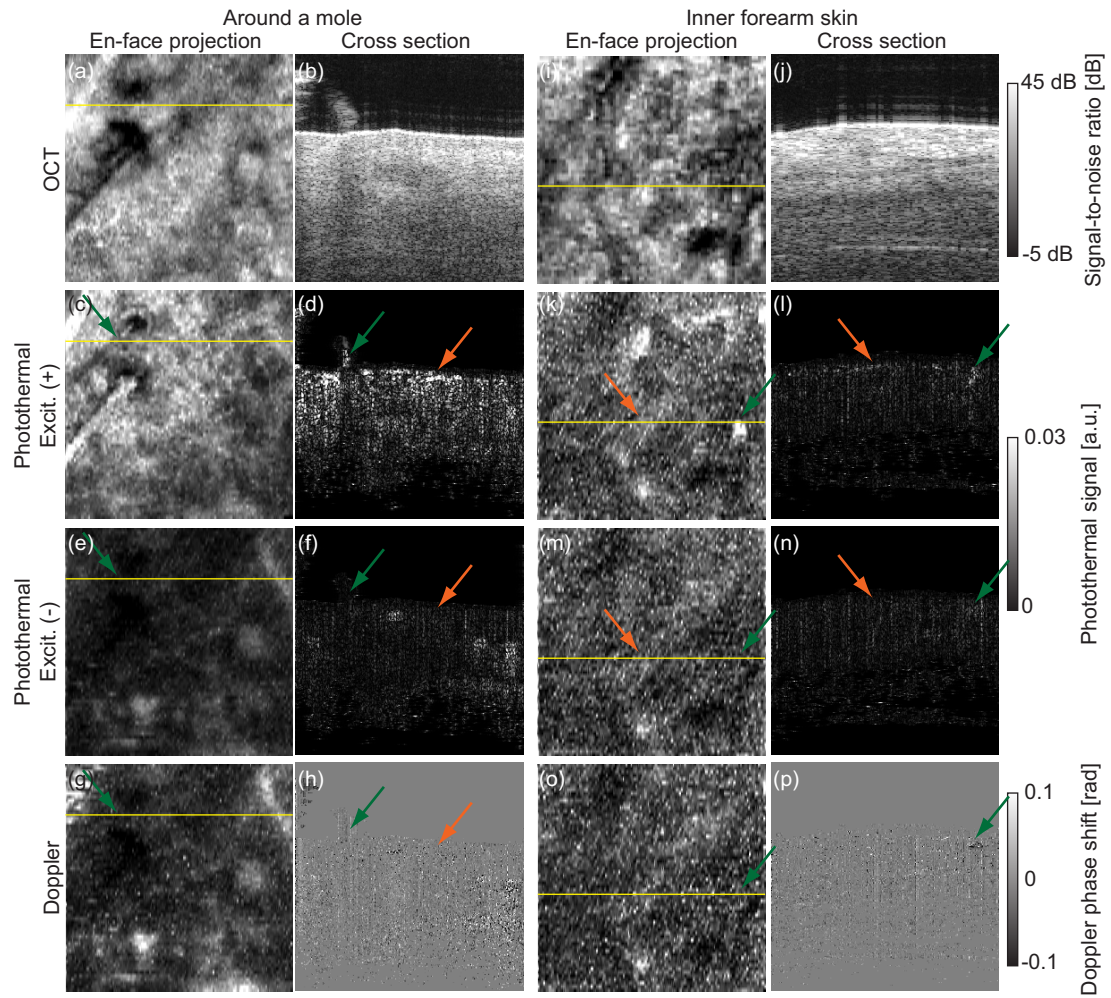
Volumes of OCT (first row) and photothermal OCT (second and third rows) images of human skin. Images in the fourth row are images of Doppler blood flow for comparison. Two volumes around a mole (a–h) and of normal skin (i–p) are obtained. *En-face* projections (left) indicate the locations of the cross-sectional images (left).
